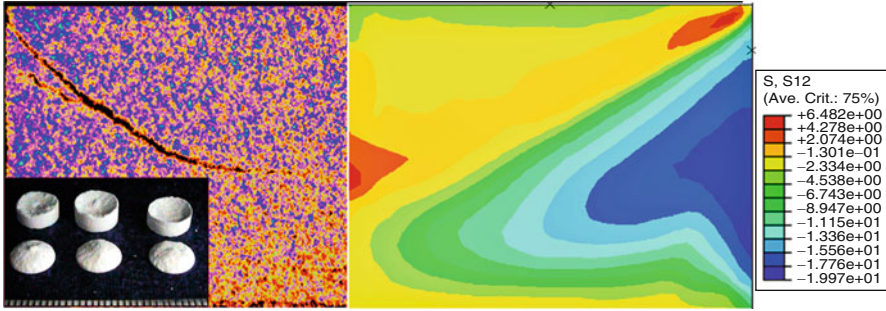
The distribution of shear stress (*right*) obtained using FEM and visual examination of X-ray computed tomographic images of ejected lactose tablets (*left*)
